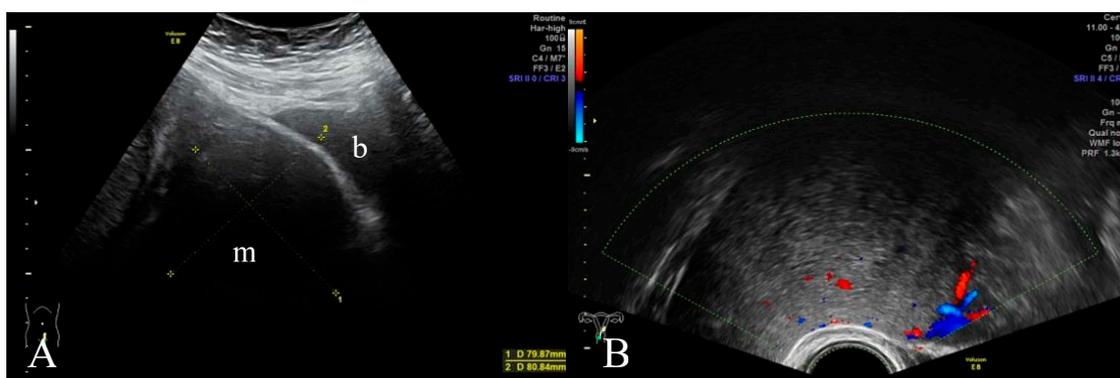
Uterine mass during pregnancy. Suspicion of growth of the mass in AU at 38 weeks of gestation (A). Ultrasonographic findings were suggestive of deviation of the labor canal, especially as seen in PU (B). b – bladder, m – mass.
